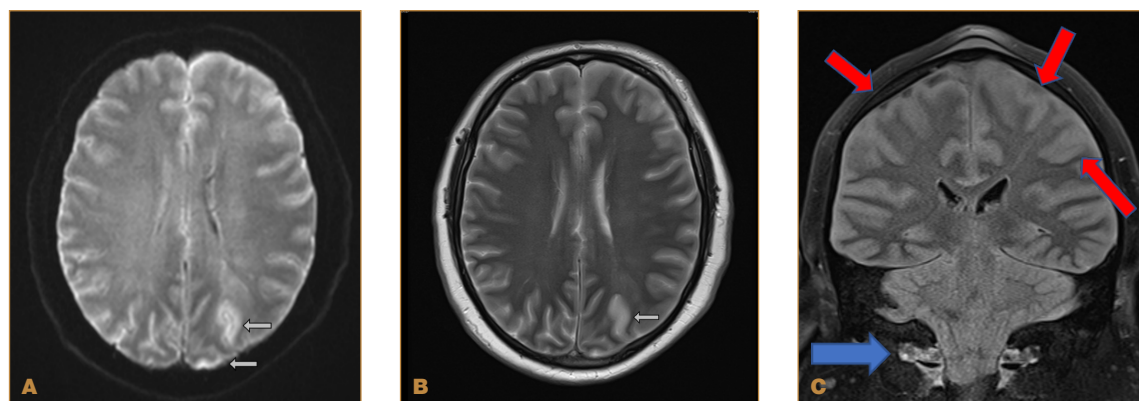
MR imaging of 1st patient
